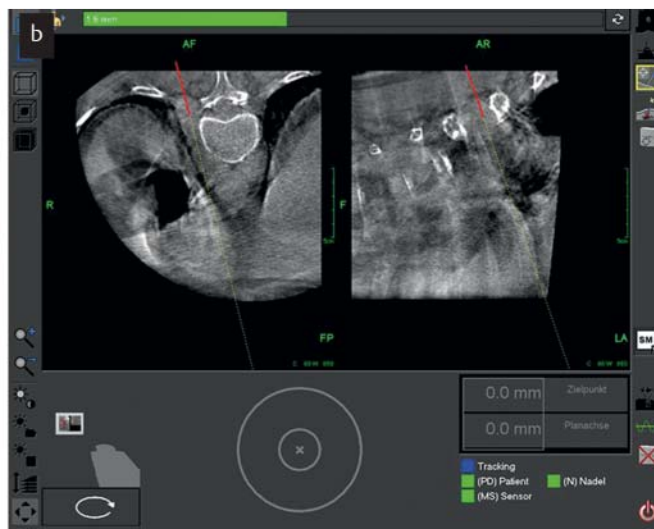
FD-CT-/EMN-gesteuerte Biopsie eines Lymphknotens innerhalb des Retrokruralraums. a Die präinterventionelle axiale MSCT-Aufnahme einer 74 Jahre alten Frau in Bauchlage zeigt multiple Lymphknoten innerhalb des Retrokruralraums. b Während der FD-CT-/EMN-gestützten Biopsie in axialer und sagittaler Projektion wird die virtuelle koaxiale Führungsnadel korrekt in einen linksseitigen Lymphknoten geführt. Die Diagnose ergab ein Rezidiv eines Lymphoms.
